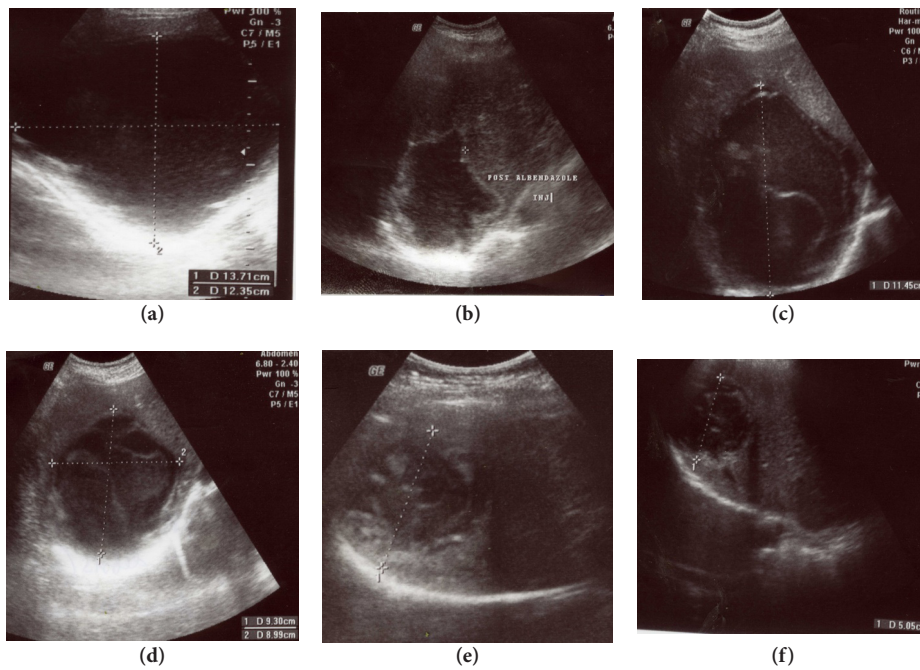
Serial follow up sonograms for patient with single right hepatic hydatid cyst treated with PAI: (a) Before intervention. (b) Partially collapsed cyst just one hour after PAI. (c) Reexpansion of the cyst with detached endocyst after one week of the treatment. (d& e) Sonogram obtained at 3rd and 6th months follow up visits showed progressive reduction in the cyst volume with progressive increasing solid component, and (f) Small pseudo-mass pattern at last follow up.
